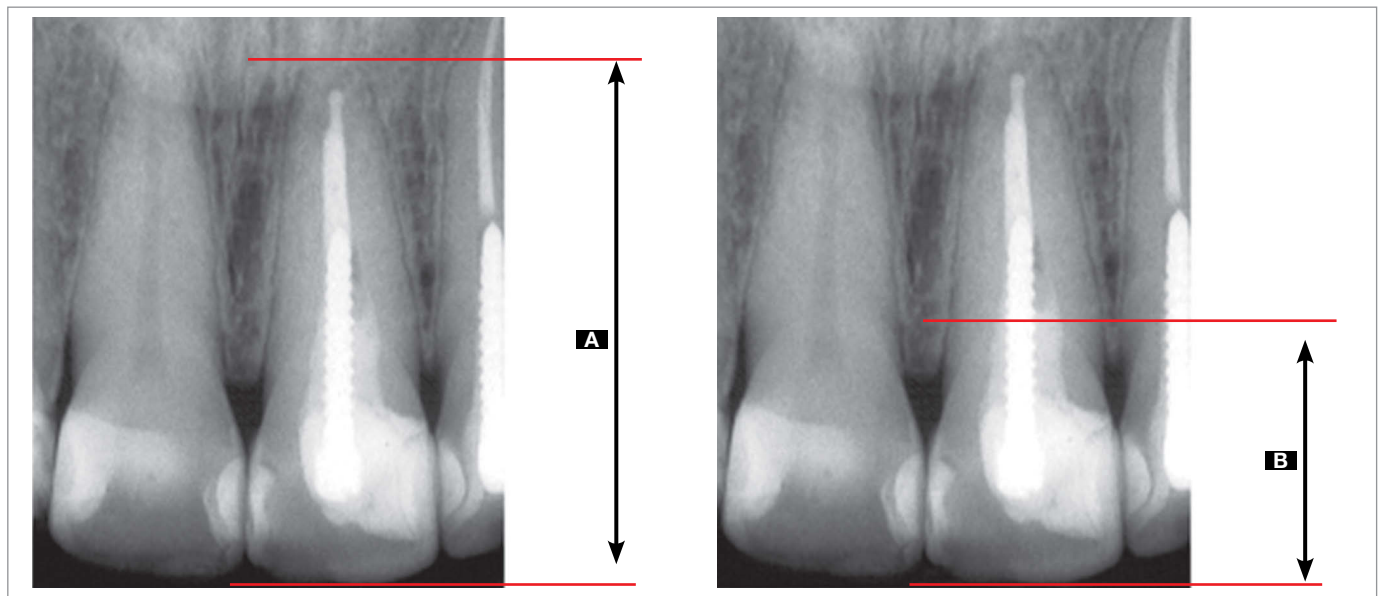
Radiograph representing the dental measurements carried out. A. Incisal-apical distance used to calculate root resorption. B. Incisal-enamel-cementum junction distance used to calculate the radiographic foreshortening/elongation factor.
